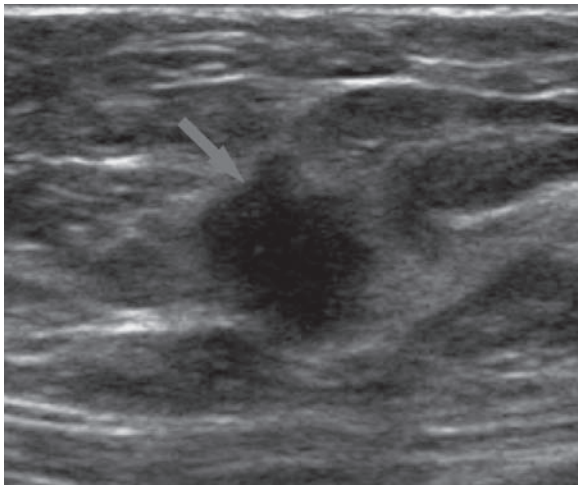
Typical sonographic features of a malignant solid mass. The hypoechoic mass (*arrow*) manifests an irregular shape with angular margins, is orientated “not parallel” to the skin (“taller-than-wide”), and is surrounded by a thick, echogenic (*white*) halo. Biopsy revealed invasive ductal carcinoma
